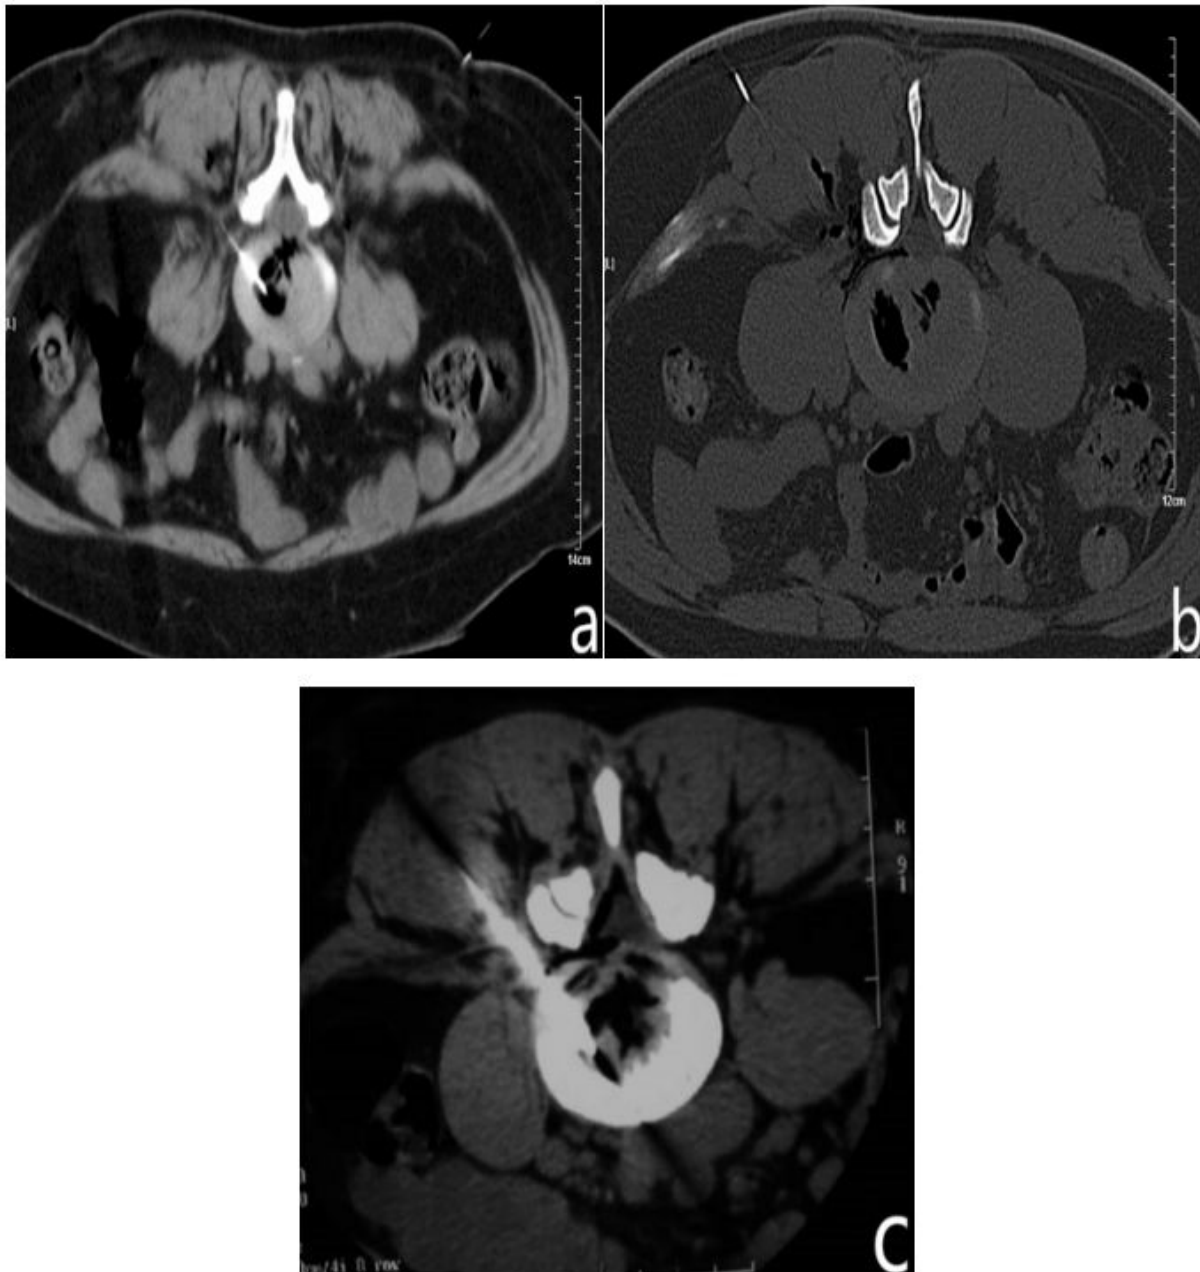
(a): grade 1 (internal rupture type). The needle tip was located at the center of the intervertebral disc or 1/3 of the middle-posterior junction. 2-3 mL of ozone gas was injected into the suspected intervertebral disc and CT showed signs of inner layer tear of the annulus fibrosus of the intervertebral disc. (b): (protrusion type). 2-3 mL of ozone gas was injected into the suspected intervertebral disc and CT showed that ozone escaped to the posterior longitudinal ligament and intervertebral foramen. (c): grade 3 (tear type). 2-3 mL of ozone gas was injected into the suspected intervertebral disc and CT showed that ozone escaped into the epidural space.
